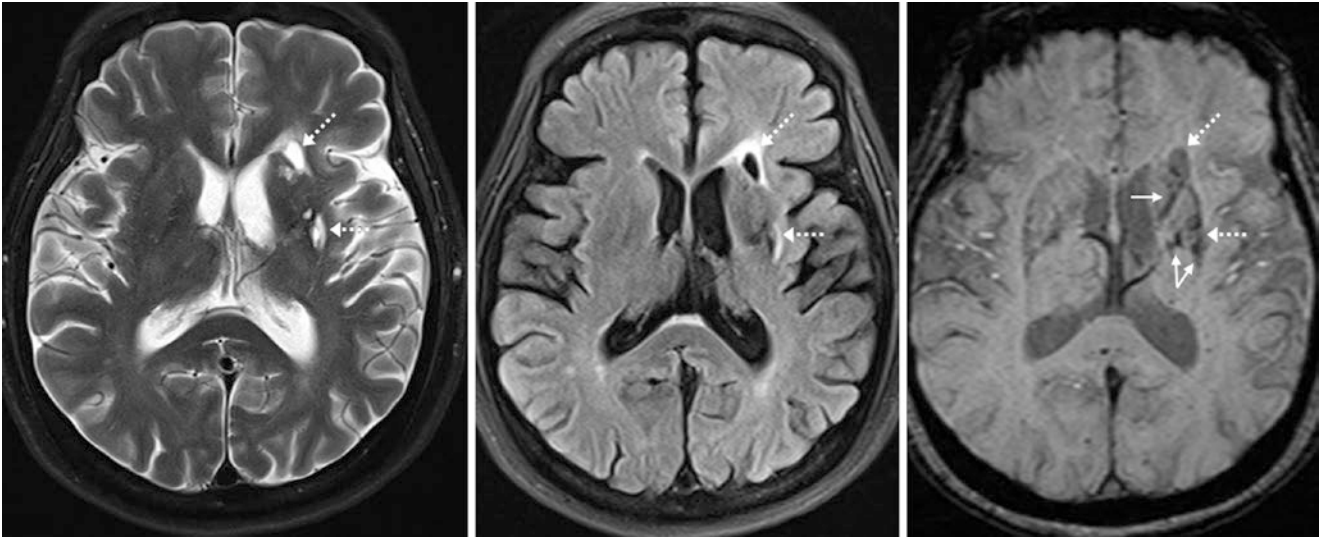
Comparison case of chronic lacunar infarcts. A 59 year old with dementia had chronic lacunar infarcts (*dotted arrows*) on T2WI (*left*), with mild surrounding hyperintense signal on FLAIR (*middle*)
